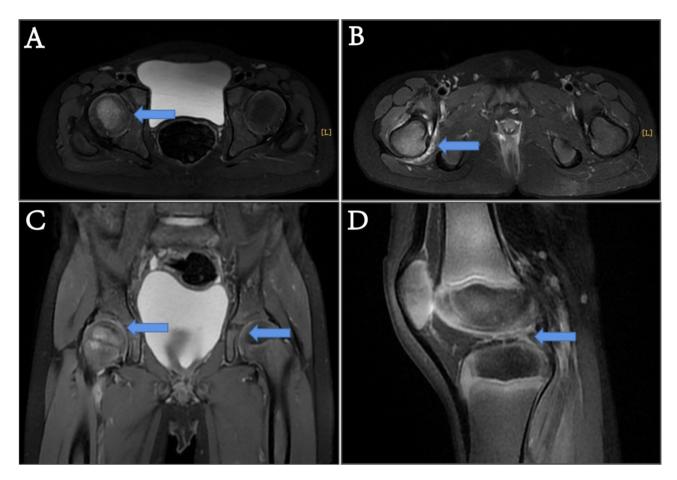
Magnetic resonance imaging of the hip and right knee articulations. (A) The occurrence of edema within the bone marrow of the proximal femur. (B) Reactive hypertrophy of the musculature surrounding the proximal femur. (C) Bilateral hip synovial membrane thickening and reinforcement. (D) The synovial membrane in the right knee exhibits thickening
